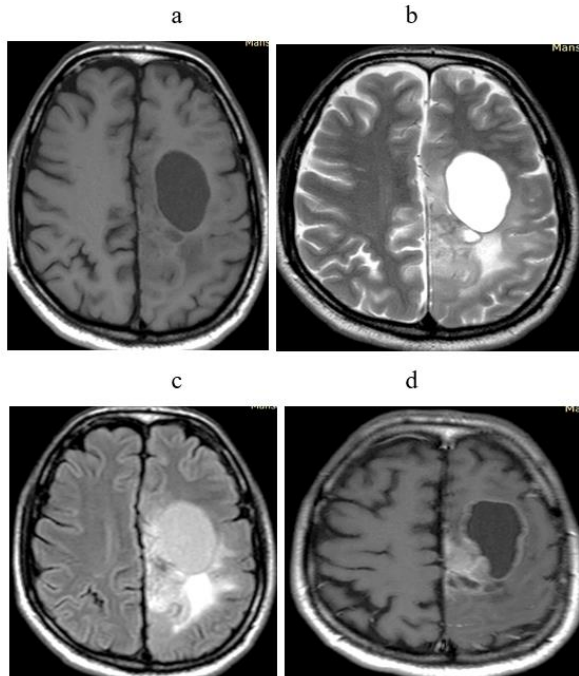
a) Axial T1 image showing low signal of the cancer. b) Axial T2 image showing left fronto-parietal SOL with surrounding edema and large cystic part with related sulci effacement, c) Axial FLAIR image demonstrating the high signal of the cancer with mild peri-cancerous edema d) axial T1 post contrast images demonstrating areas of nodular and marginal cancer enhancement.
